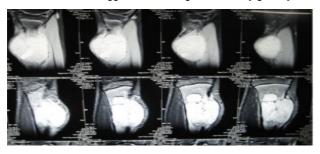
MRI of right proximal leg showing hyper dense lesion in the diaphyseo-metaphyseal region with cortical destruction and soft tissue invasion in the proximal tibia
